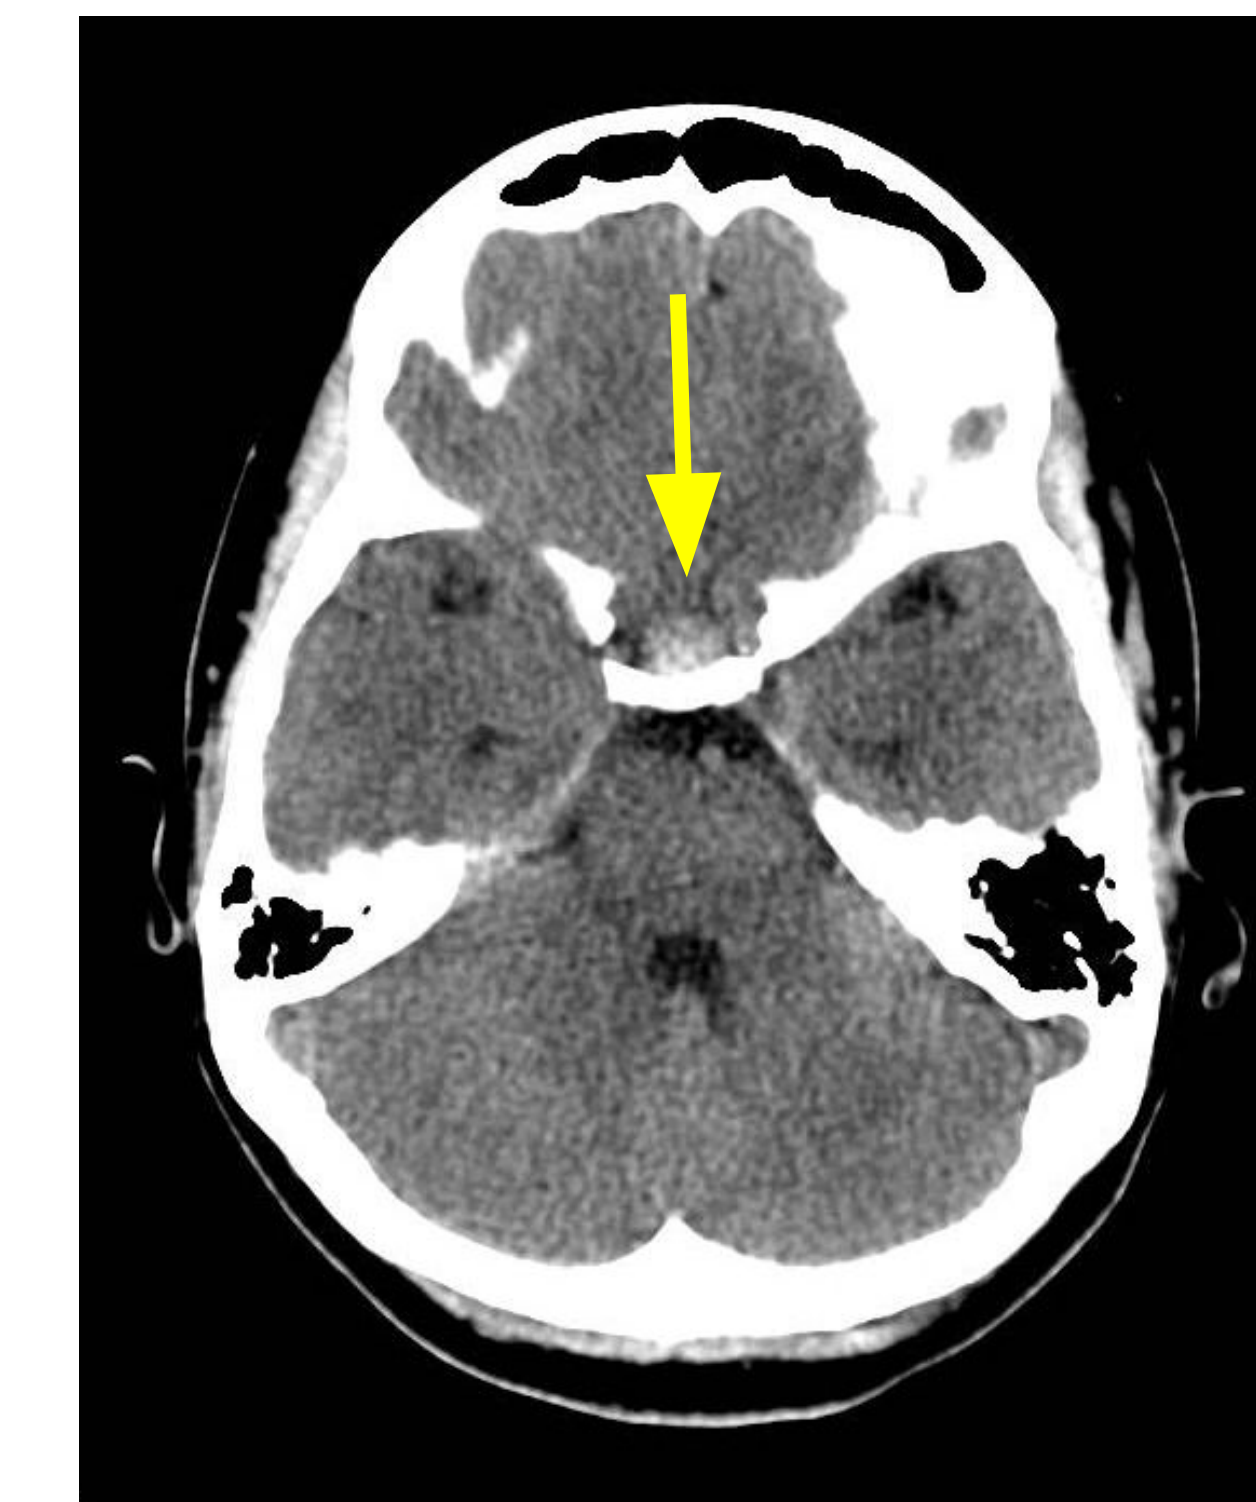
Axial view of the pituitary hemorrhage (arrow) on CT Head without contrast.
